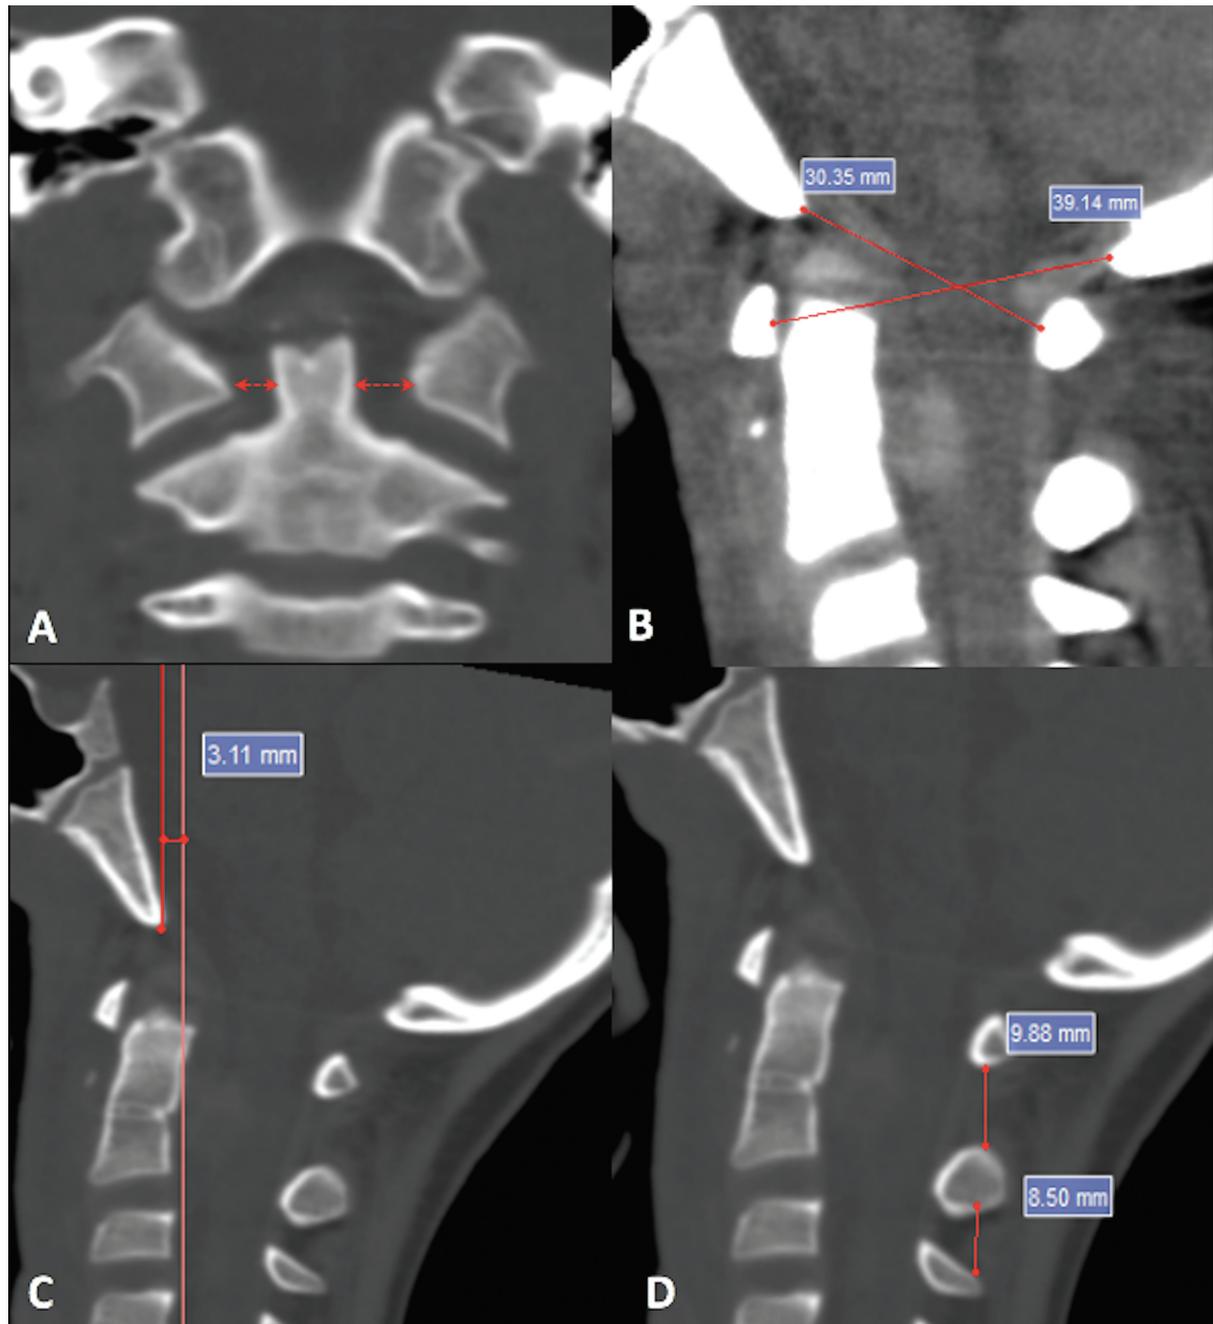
Admission cervical computed tomography (CT) scan. (A) Slightly Left–right asymmetry between the atlas and vertebrae axis in the coronal plane. (B) Sagittal CT scans showing a normal Powers ratio measurement (0.79; normal ≤ 1), but an epidural collection in the upper cervical canal. (C) Normal Harris' basion-axis interval (3.11). The normal distance is between 12 and 0 mm in children. (D) Normal Sun'si ratio (1.16). The interspinous ratio is indicative of atlanto-occipital dislocation (AOD) by a C1–C2/C2–C3 ratio of more than 2.5.
